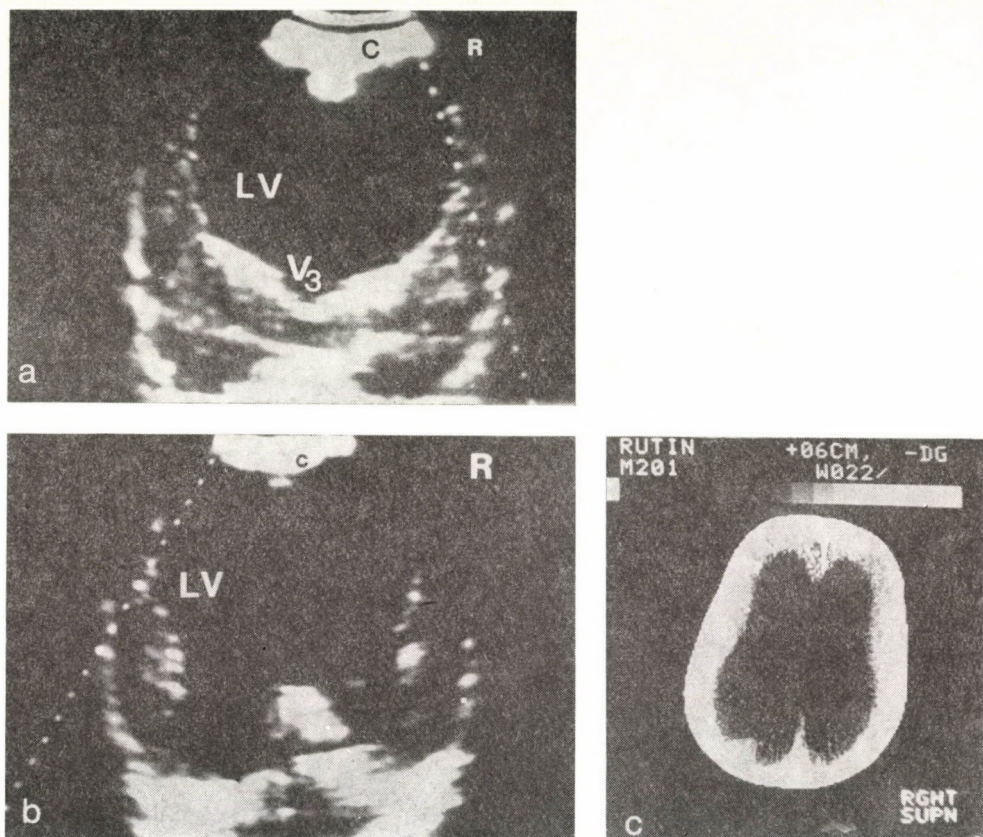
Large internal hydrocephalus in two years old boy with macrocephalus with consequential occlusion of aqueduct. a, b) The frontal first and third sections (lateral ventricle) (LV), C: brain mantle, c) Comparison with CT shows excellent agreement. R: right direction
